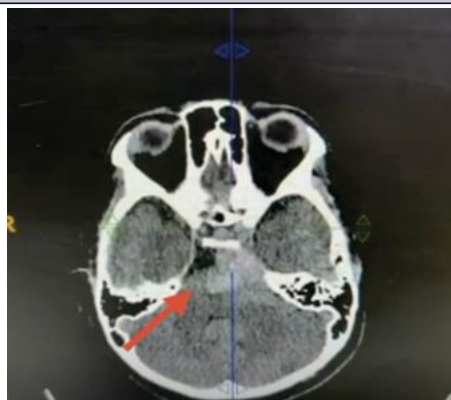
Plain CT brain (axial) showing hyperdense lesion in left cerebellopontine angle/prepontine region causing mass effect on pons; initial differential diagnosis included extra-axial lesion versus hemorrhage.
